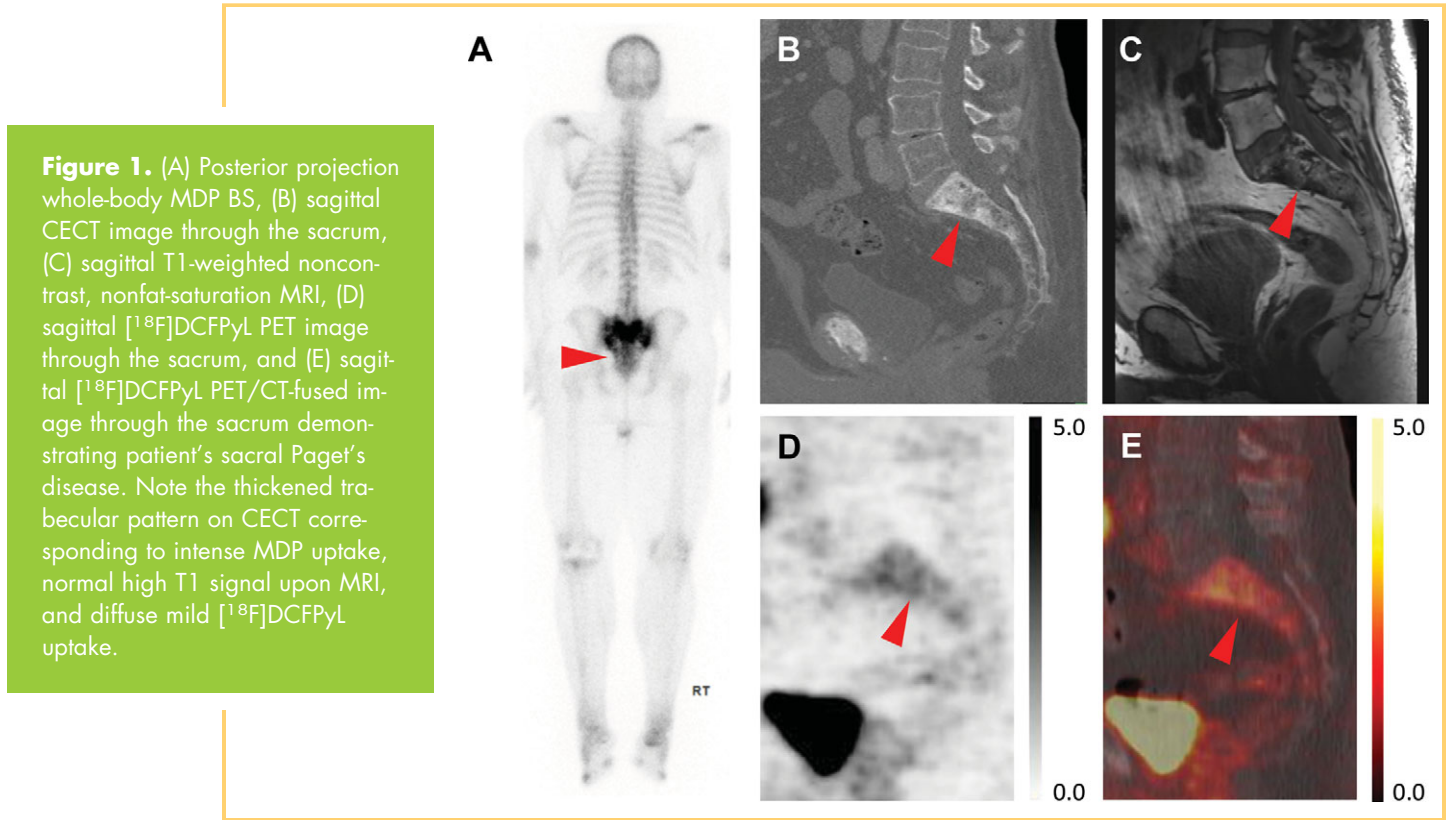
(A) Posterior projection whole-body MDP BS, (B) sagittal CECT image through the sacrum, (C) sagittal T1-weighted noncontrast, nonfat-saturation MRI, (D) sagittal [¹⁸F]DCFPyL PET image through the sacrum, and (E) sagittal [¹⁸F]DCFPyL PET/CT-fused image through the sacrum demonstrating patient's sacral Paget's disease. Note the thickened trabecular pattern on CECT corresponding to intense MDP uptake, normal high T1 signal upon MRI, and diffuse mild [¹⁸F]DCFPyL uptake.
